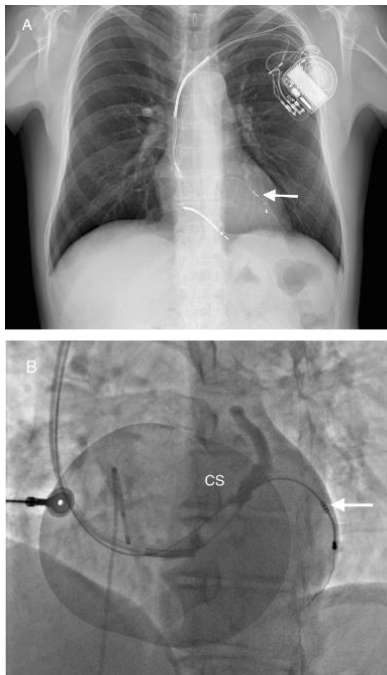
A) Chest x-ray in the postero-anterior projection showing the leads and the device. The white arrow indicates the lead positioned into a coronary sinus (CS) collateral vein. B) CS venogram showing thrombotic occlusion of the CS side-branch where the active-fixation lead is located (white arrow).
